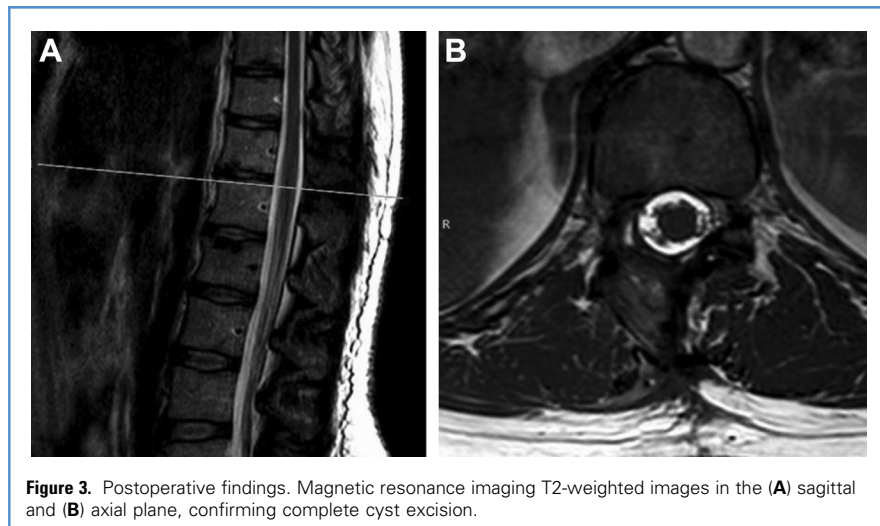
Postoperative findings. Magnetic resonance imaging T2-weighted images in the (A) sagittal and (B) axial plane, confirming complete cyst excision.
